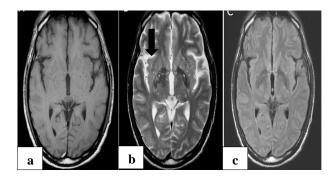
Magnetic resonance imaging (MRI) of the brain (a) T1W, (b) T2W, and (c) FLAIR sequences showing dilated perivascular Virchow-Robin spaces with gelatinous pseudocysts (black arrow) suggestive of neurocryptococcosis.
